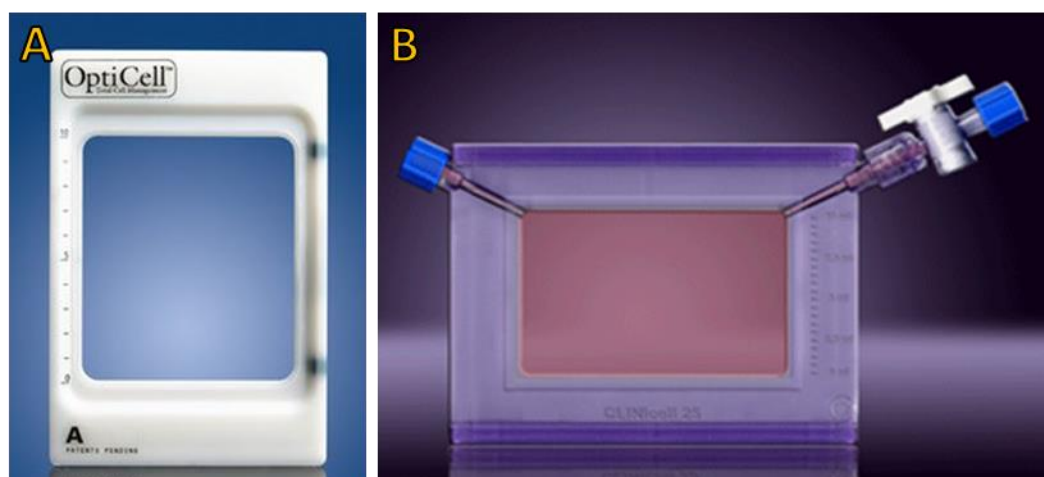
Commercially available cell culture vessels used in ultrasound exposures. *A: The OptiCell (Thermo Fisher Scientific, US, discontinued); B: The CliniCell (Mabio, FR). Images reproduced with permission from the manufacturers.*
